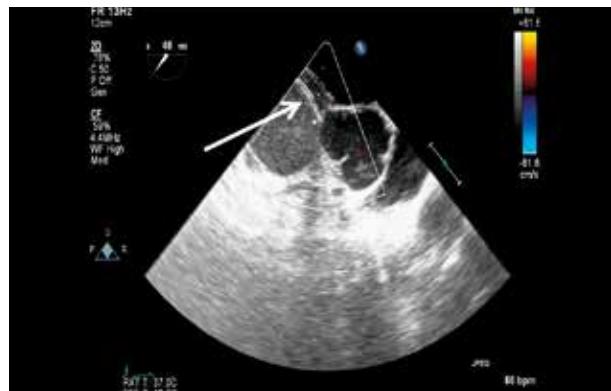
Transesophageal echocardiography image of the occluder immediately after implantation (white arrow)
